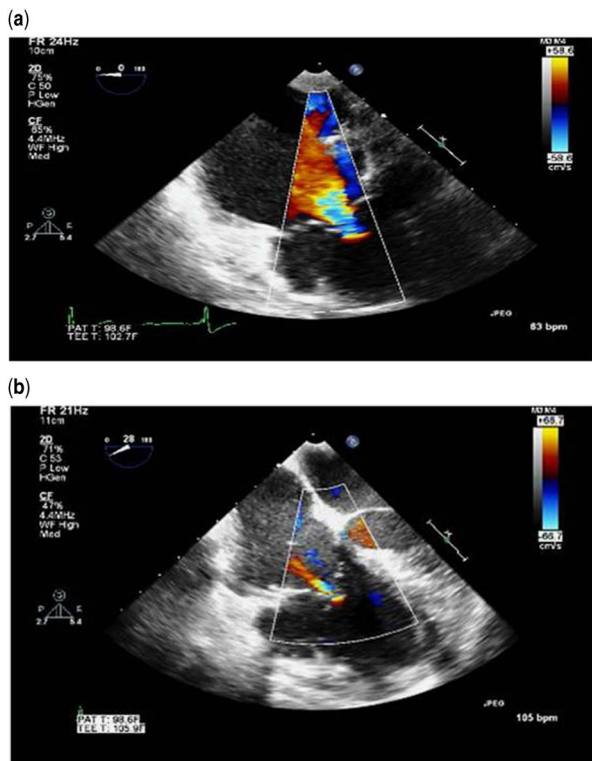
Colour flow Doppler echocardiograms showing preoperative severe tricuspid regurgitation (a) in a patient with Uhl's anomaly who underwent ringed annuloplasty with a # 28 ring. The postoperative result is shown (b) with significantly improved tricuspid valve function.⁵
